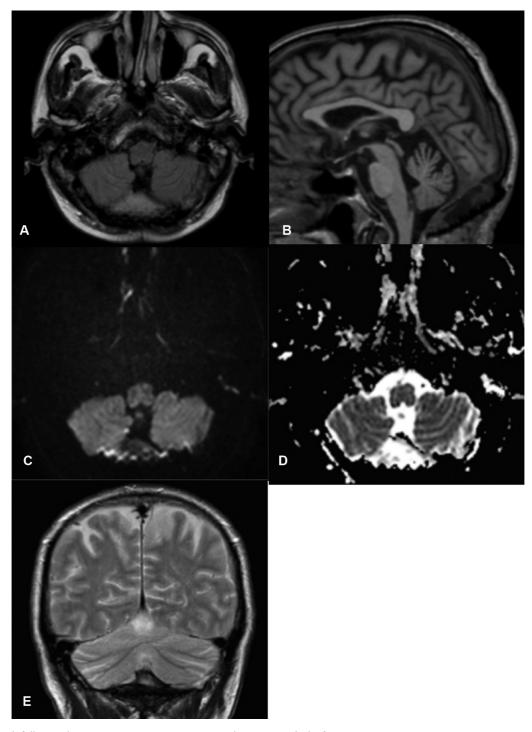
6-month follow-up brain magnetic resonance imaging documenting lack of recurrence.
